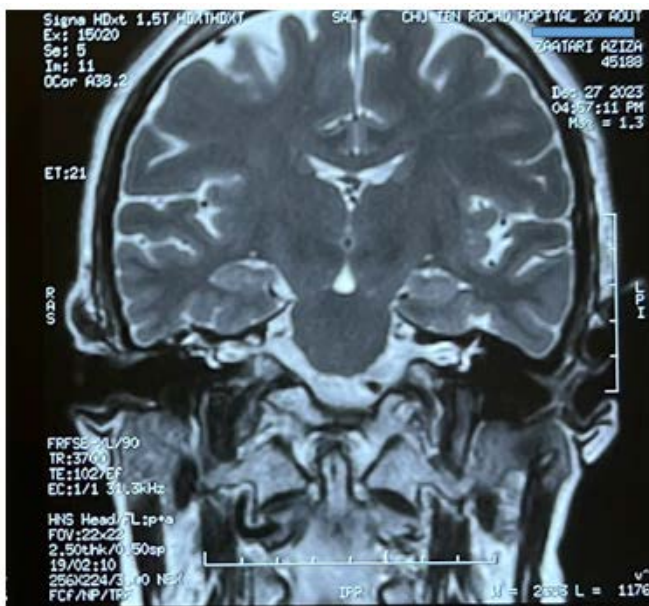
MR imaging of the temporal bone showed a loss of the annular appearance of the right semicircular canal.
